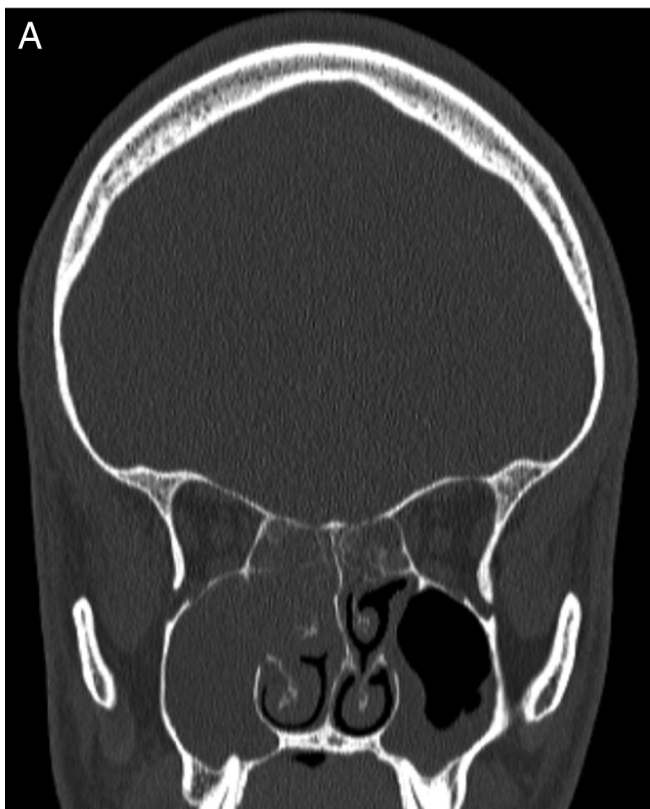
Coronal CT (A) and T1 fat suppressed MRI with gadolinium (B) images demonstrating a soft tissue mass in the posterior ethmoid sinuses.
